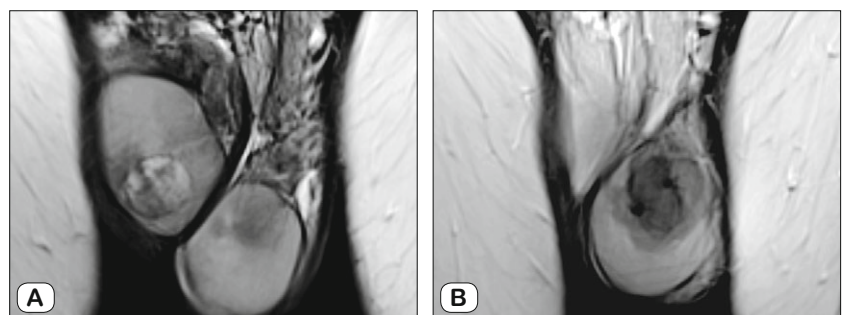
Distinguishing NSCT from seminoma testis using MRI.
